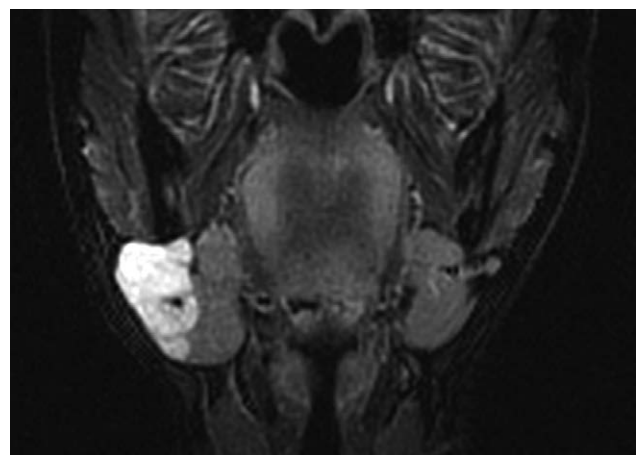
MRI finding. MRI STIR sequence coronal image showed a 38×29 mm well-circumscribed, lobulated mass with high signal intensity attached with the submandibular gland.
